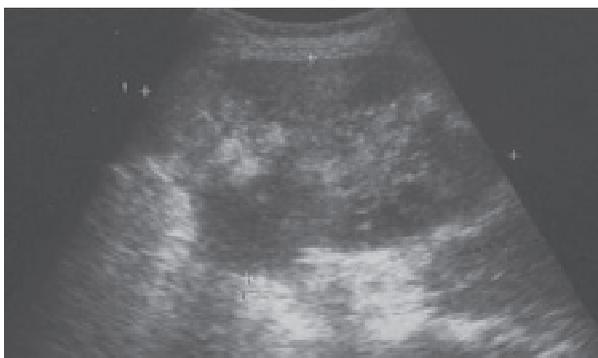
Ultrasound evaluation; a heterogenous well-defined mass was detected in the left anterior pararenal space. The mass was mainly hypoechoic, containing hyperechoic areas. On Doppler US the mass was mainly avascular in nature.
